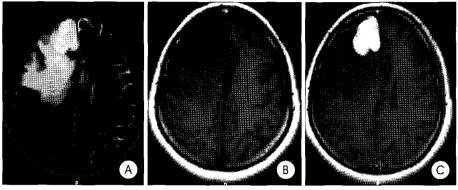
Magnetic resonance(MR) image of the brain revealing $2\times 2cm$ sized mass on the right frontal convexity, It is iso-signal on T2-weighted MR image (A), low signal intensity on T1-weighted MR image (B), inhomogeneously enhancing on T1-weighted gadolinium-enhanced MR image (C).
